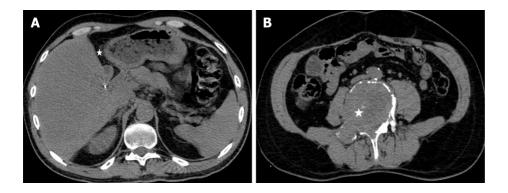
Abdominal and pelvic computed tomography after left hepatectomy-axial images. A: There is no tumor reccurence on surgical margin (white star) and no focal lesions in right liver lobe; B: An ill-defined lytic lesion (white star) of the L5 vertebral body is seen without periosteal reaction, representing solitary osseous metastasis of liver sarcoma.
